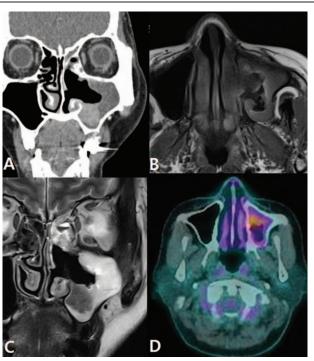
Coronal computed tomogram showing a hyperattenuated remnant lesion is in the left maxillary sinus (A). MRI showing a heterogenous signal intensity in the T1 (B) and T2 (C) weighted image. PET CT revealing a hypermetabolic mass in the left maxillary sinus (maximum SUV=5.96), but showing no invasion to adjacent structures (D). CT=computed tomography, MRI=magnetic resonance imaging, PET=positron emission tomography, SUV=standardized uptake value.
